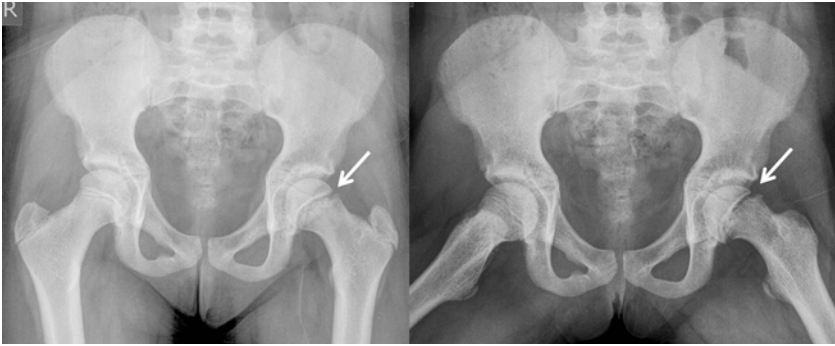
Left sided slipped capital femoral epiphysis. The “frog” lateral radiograph shown on the right is important to detect the abnormality, which is difficult to see on plain anteroposterior radiography
